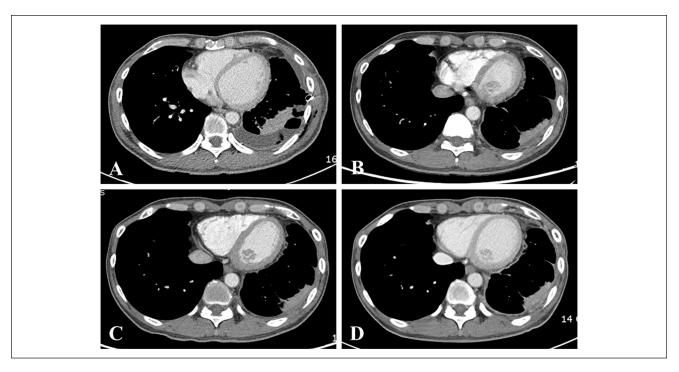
Computed tomography scans of the patient. (A) Baseline taken in December 2017 showing diffuse thickening of the left pleura with pleural effusion. (B) Taken in September 2018. (C) Taken in January 2019. (D) Taken in June 2019. No significant interval changes are visible.
